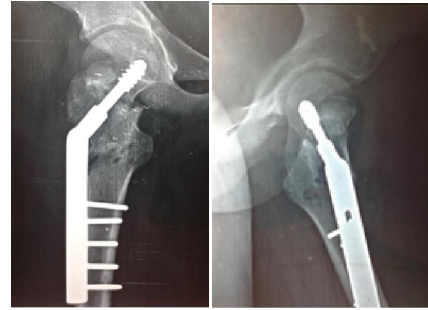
Post operative x-ray after fixation
